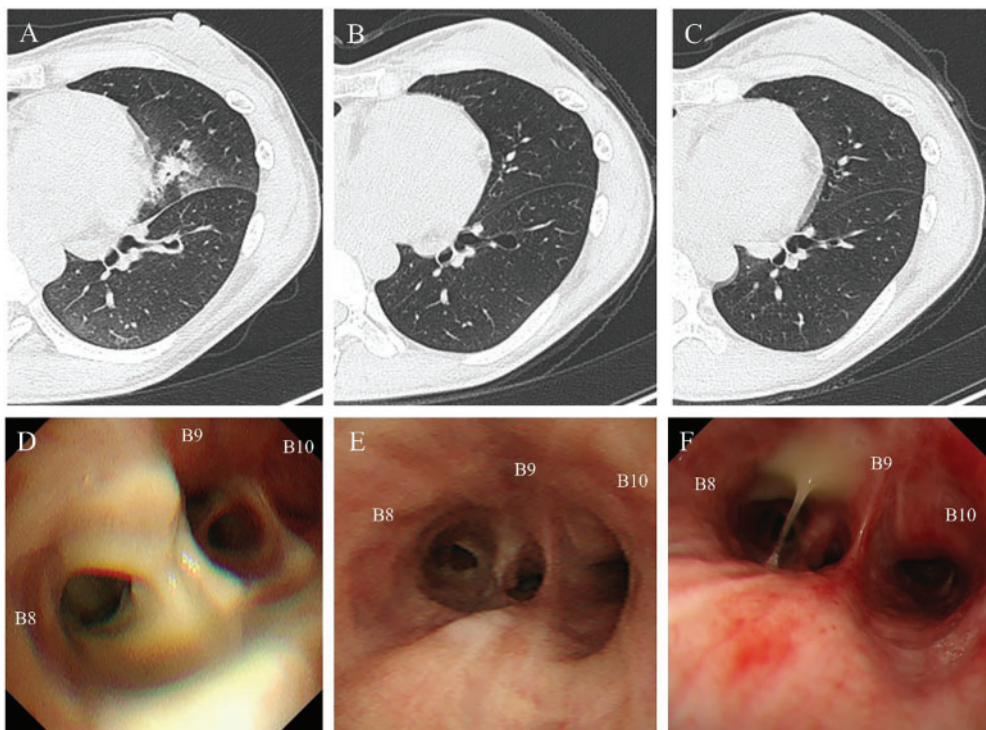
Patient's computed tomography and bronchoscopy images. (A) Diagnosis: CT shows bronchial wall thickening, bronchiectasis, consolidation, opacities, and upper lobe changes; (B) Six months: CT shows improvement in all parameters except bronchiectasis; (C) Three years: CT shows near-complete resolution; (D) Diagnosis: Bronchoscopy shows necrotic tissue and purulent mucus in the left B8 bronchus; (E) Six months: Bronchoscopy shows resolved necrosis and bronchial scarring; (F) Three years: Bronchoscopy shows improved scarring; purulent sputum persists.
